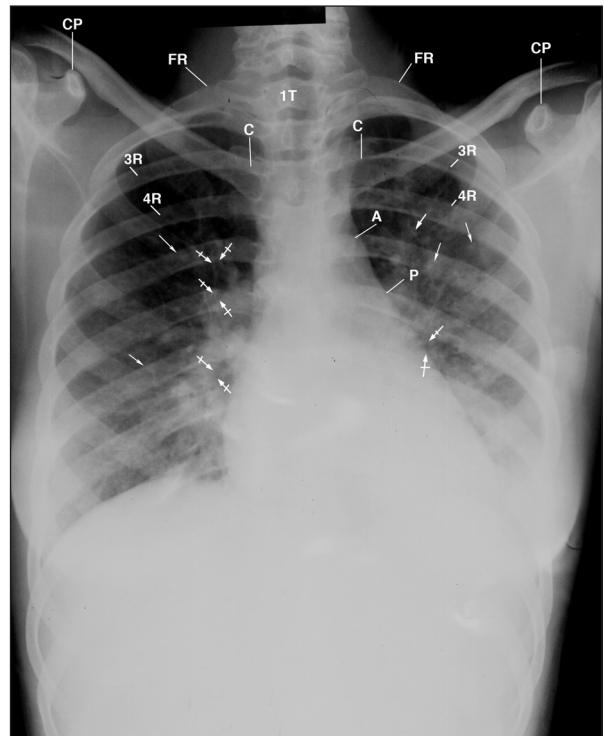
This posteroanterior chest radiograph displays multiple amorphous nodular densities (arrows) in both lungs; anterior rotated clavicles over the posterior third intercostal spaces (between the posterior third and fourth ribs), hazy amorphous density in the left lung obscuring the left hemidiaphragm and the adjacent heart margin, reflecting a large pleural effusion, and air bronchograms (bar arrows). Observe the hunched-up, rounded shoulders, with the right higher than left suggesting laxity of the sling/erector muscles (trapezius, levator scapulae, serratus anterior) of the shoulder.
